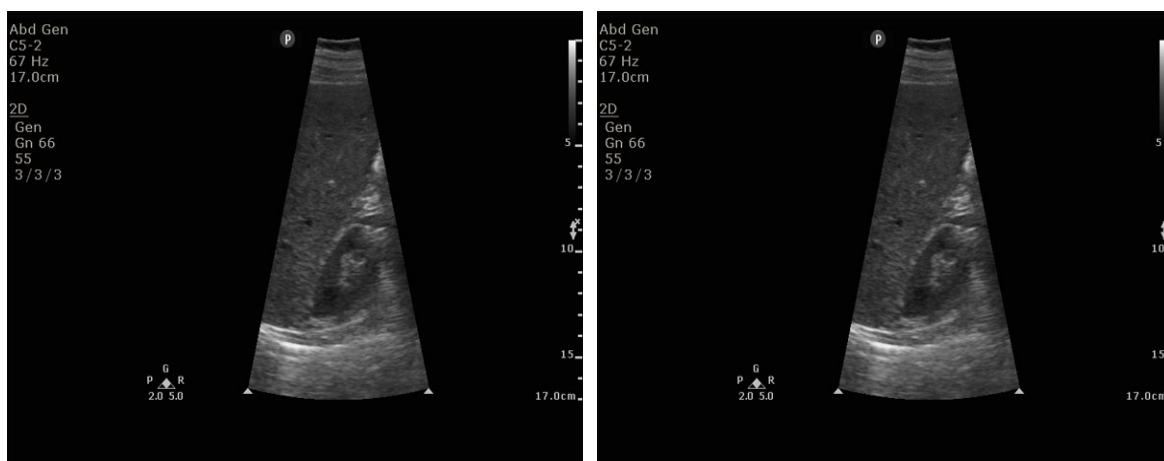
A - Real Ultrasound Machine
